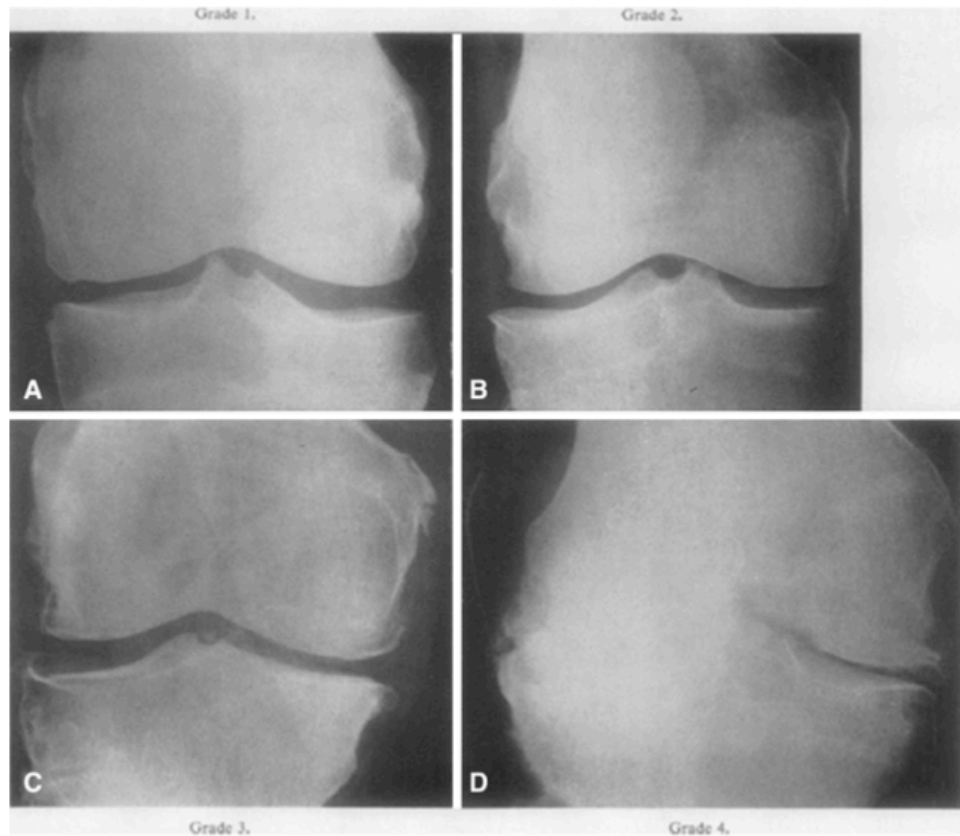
Radiographs of the different severities of knee OA as graded by the Kellgren Lawrence scale (as described by Kohn et al., 2016): (A) Grade 1 demonstrates doubtful narrowing of the joint space and possible osteophyte formation. (B) Grade 2 demonstrates definite joint space narrowing and definite osteophytes. (C) Grade 3 shows definite narrowing of the joint space, moderate osteophyte formation, and possible bony deformation of bony ends. (D) Grade 4 demonstrates large osteophyte formation, severe narrowing of the joint space with sclerosis, and definite deformity of the bony ends. Image reprinted from Kellgren and Lawrence, 1957.
